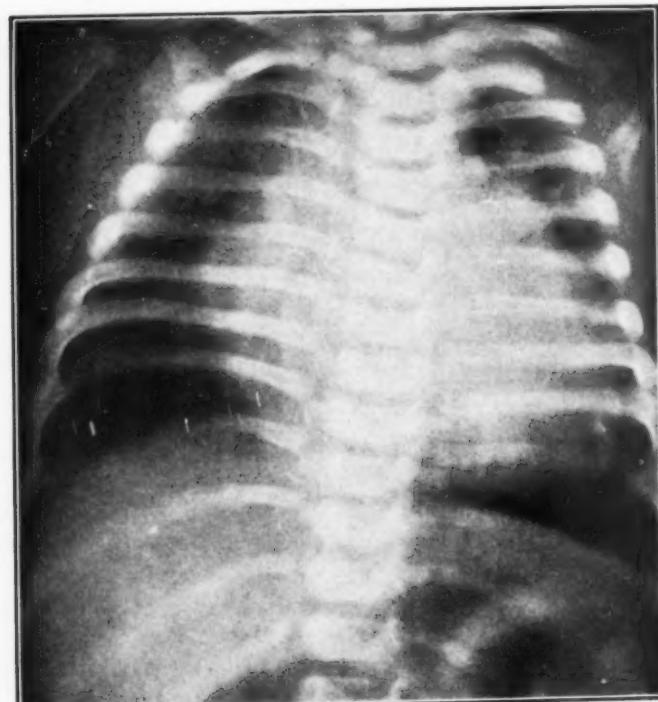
Roentgenogram of patient at age three months.
